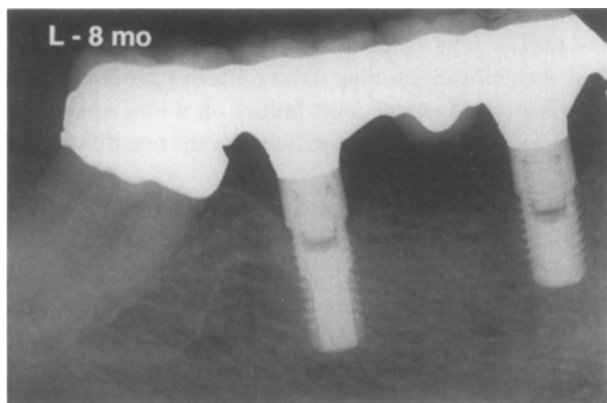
Radiograph 8 months after placement of definitive prosthesis reveals molar abutment intrusion of approximately 1 mm and some cuspid abutment intrusion (L = 8 months).
